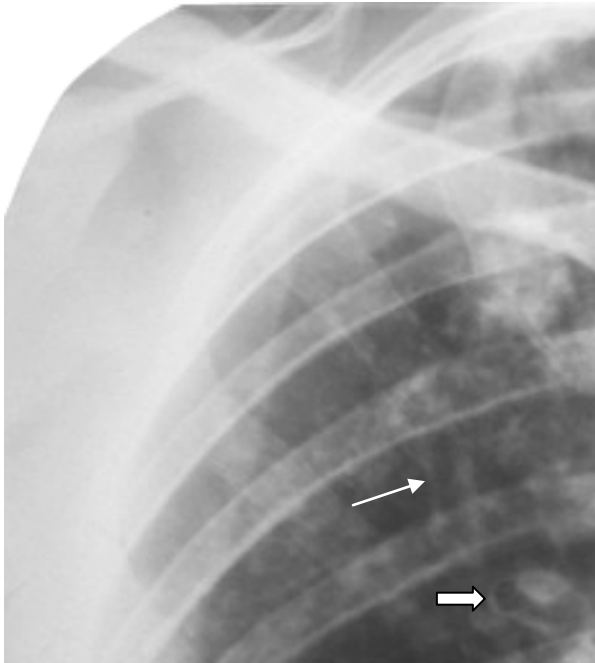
Fragment radiograph of chest in direct projection. Parallel linear shadows (arrow) and ring-shaped shadow (thick arrow) caused by peribronchial development of connective tissue. A chronic bronchitis
